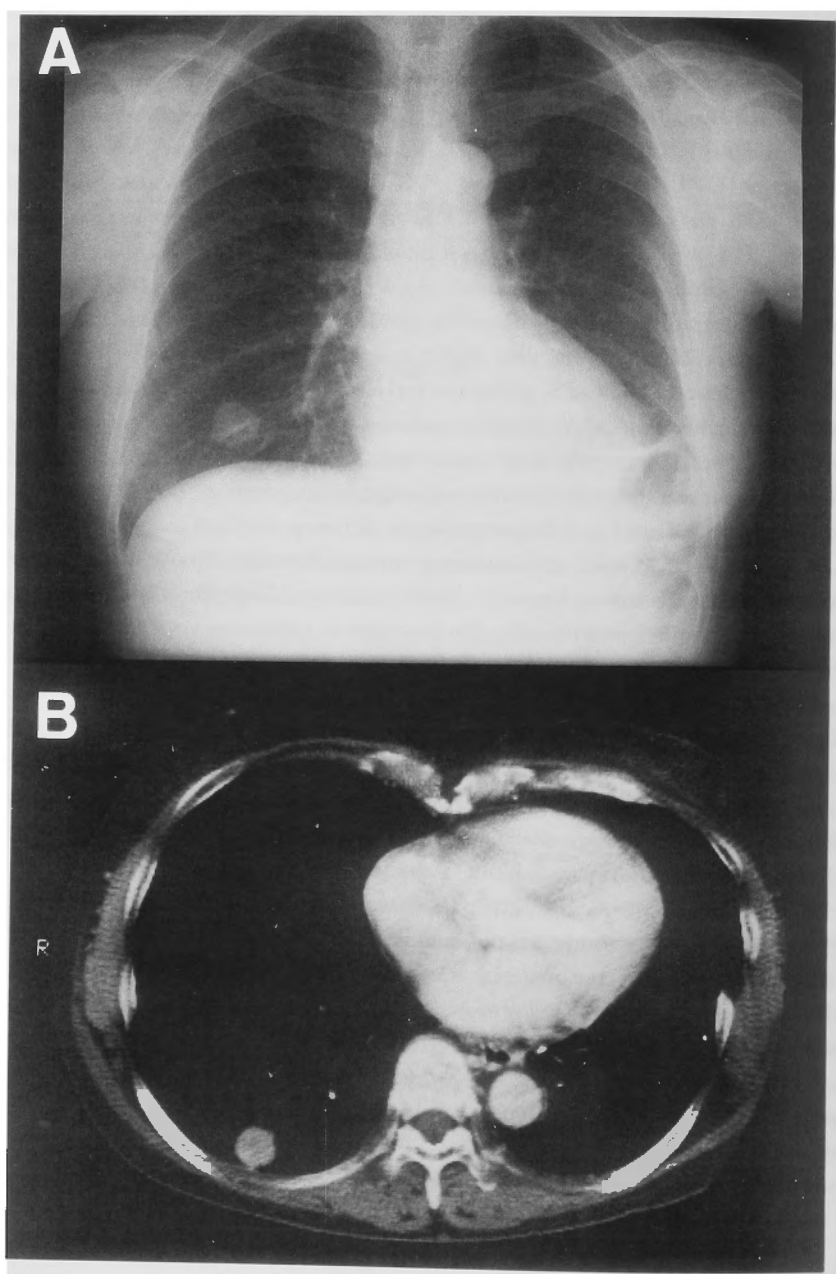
Chest X-ray and chest CT examination in case 1. In the right lower pulmonary field (S₁₀), a shadow of a nodular tumor 2 cm in diameter was observed.
